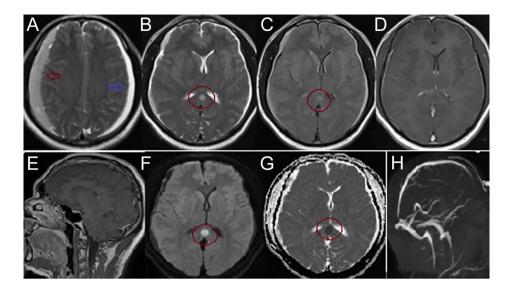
T2-weighted axial image (A) shows a subdural hematoma in the right hemisphere (red arrow) and subdural effusion in the left hemisphere (blue arrow). Axial T2-weighted (B) and fluid-attenuated inversion recovery (C) images demonstrate a round focal hyperintense lesion in the mid-splenium of the corpus callosum (circles). Axial (D) and sagittal (E) contrast-enhanced T1-weighted images show a lack of lesion enhancement but diffuse leptomeningeal enhancement. The lesion reveals restricted diffusion with a hyperintense signal on the diffusion weighted image (F, circle) and hypointensity on the apparent diffusion coefficient map (G, circle). Axial images (B-D) show thinning of the lateral ventricles. There is a caudal displacement in the cerebellar tonsils on the sagittal contrast-enhanced T1-weighted image (E). Enlargement of the cortical veins, superior and inferior sagittal sinuses, and sinus rectus was observed in cranial magnetic resonance venography (H).
